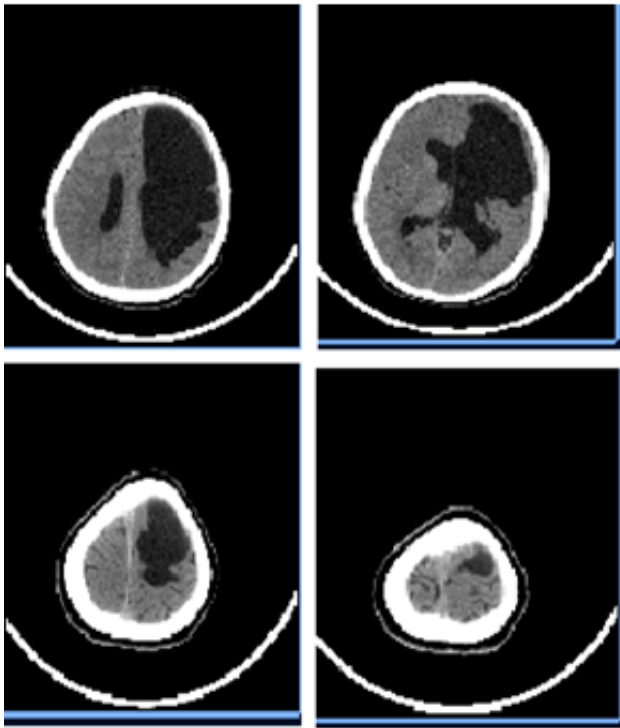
CT Brain shows CSF density lesion measuring 107 x 49 75mm (AP X TR X SI) in left fronto partial region
